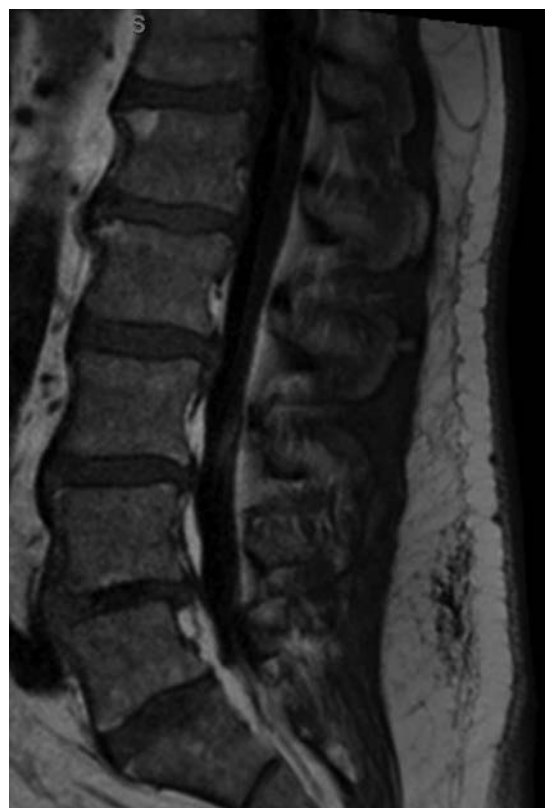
A man with epidural lipomatosis. T1 sagittal MR image shows high-signal-intensity fat around the thecal sac, with marked narrowing at L5.
